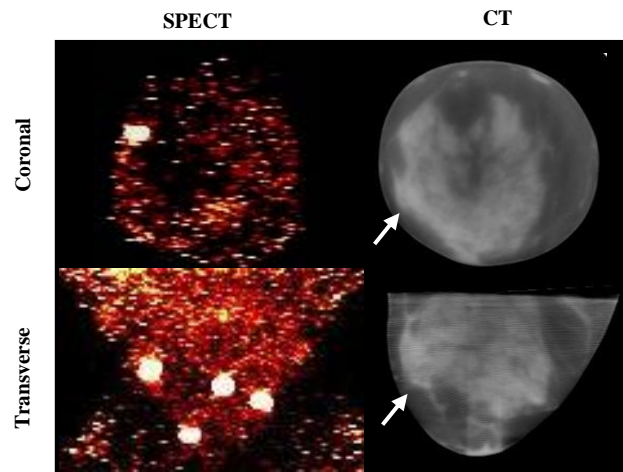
Reconstructed images of the (LEFT) SPECT (shown as a MIP image) and (RIGHT) CT slice of the right breast. Although there was no visible uptake of the radiotracer in the SPECT image, there was one suspected lesion seen in the CT images (shown by white arrow). The bright white spots on the SPECT images are the fiducial markers.
